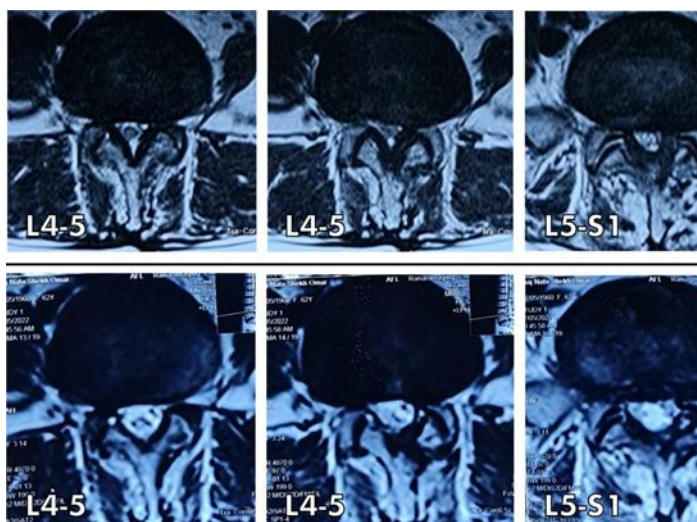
Spine MRI of a 62-year-old female. The top MRI shows L4-L5-S1 stenosis preoperatively and the bottom MRI shows the postoperative decompression through left ULBD.
